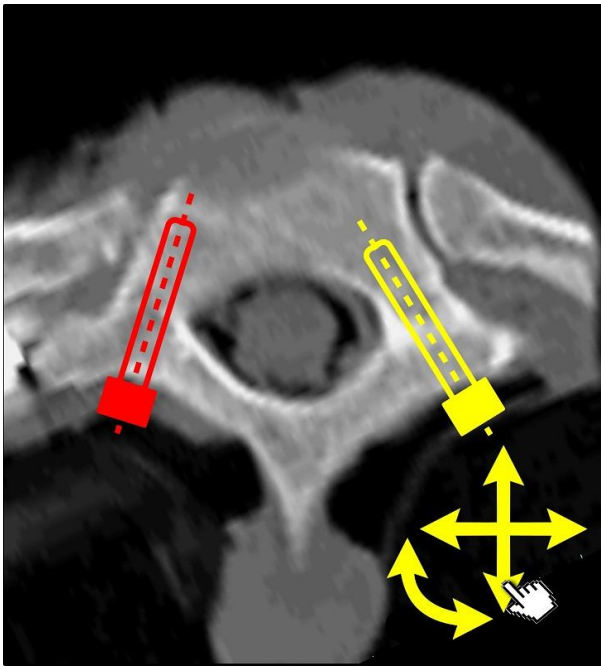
2d Visualization of Screw placements on axial CT image of T1.
